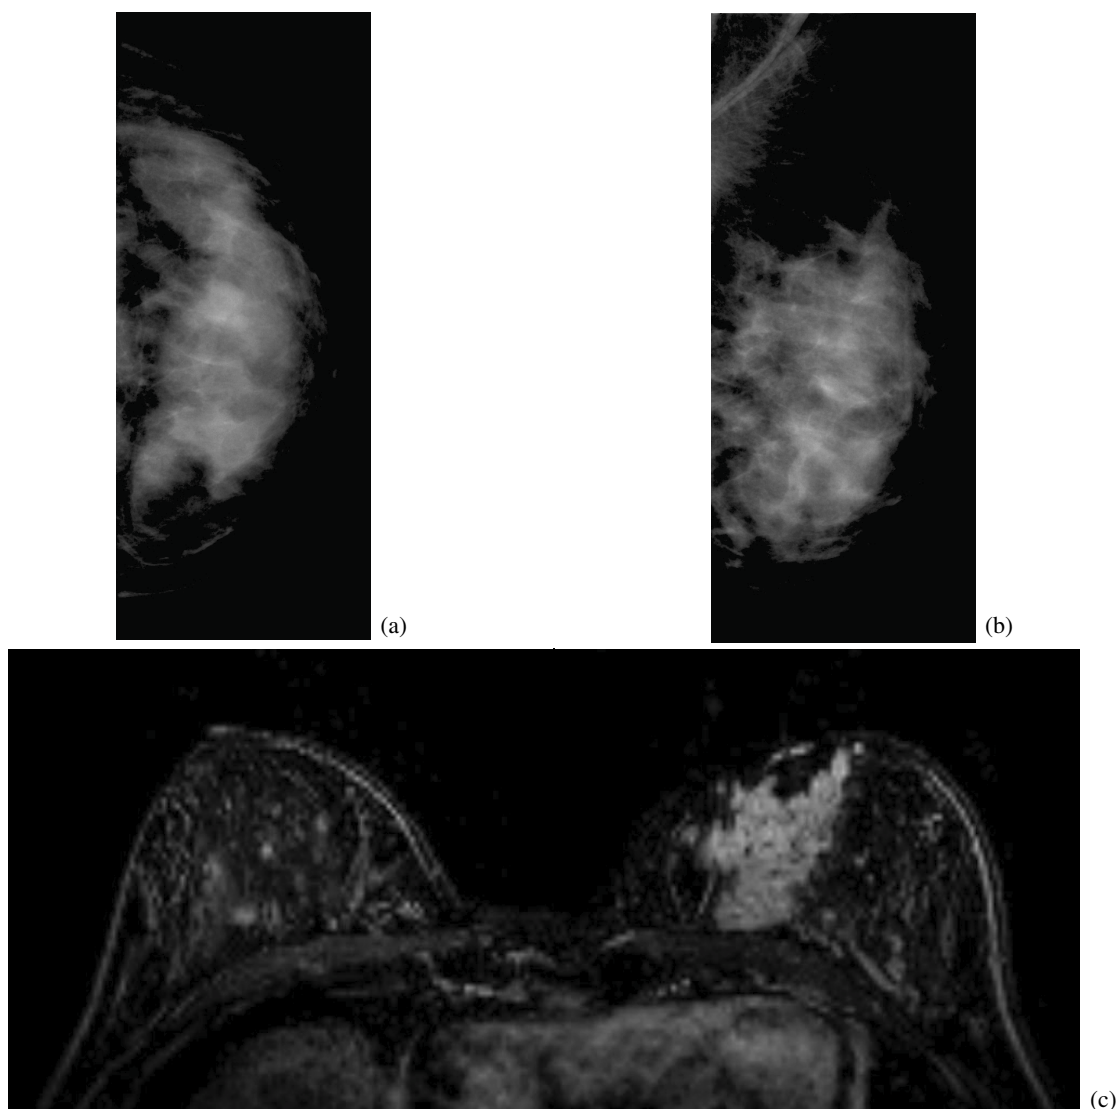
(a), (b) The mammography of a 39-year-old woman obtained during annual screening because of a familial history of breast cancer. No abnormalities were seen. (c) The MRI examination obtained on the same day. Strong irregular enhancement in the medial part of the left breast was detected. Pathology revealed a DCIS grade 3.
